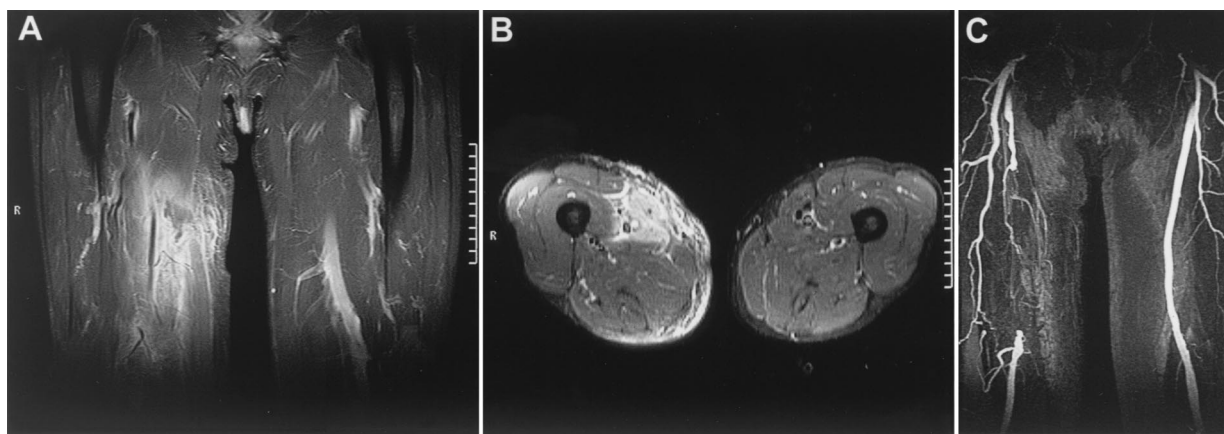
Cross-sectional magnetic resonance imaging of the right thigh and angiography of the arteria femoralis and its area of distribution. An abnormal signal intensity of the psoas muscle closely approximating the groin is shown with longitudinal (A) and sagittal (B) sections. Intravenous contrast is accumulated in the infected area. An angiogram of the right arteria femoralis and its collaterals is shown (C). R, righthand side. Scale bars show centimeters.
